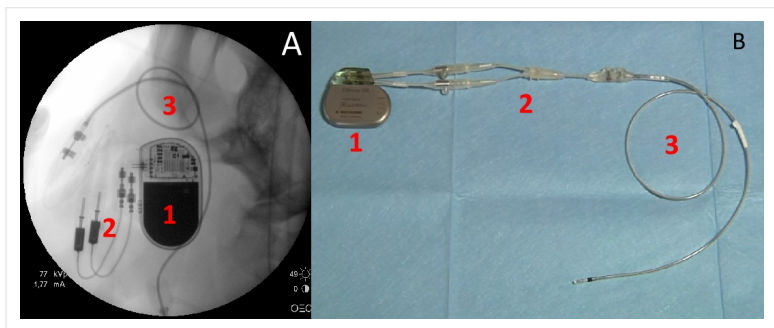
Heart pacing unit – X-ray (A) and photography (B) of dual-chamber pacemaker (Effecta, Biotronik SE & Co. KG, Germany, 1), "Y" shaped adapter (2) and ventricular pacing lead (3).
